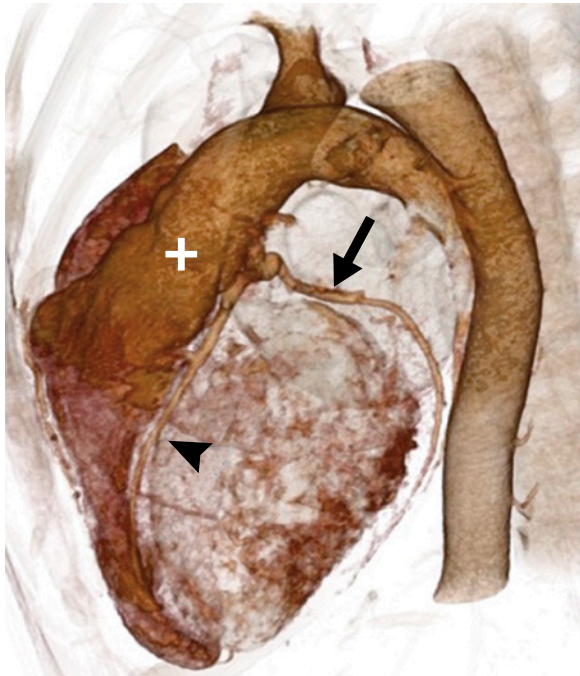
Three-dimensional CT volume rendering shows the left anterior descending coronary artery (arrowhead) and left circumflex coronary artery (arrow) arising from the left inferior pulmonary artery (+). Image courtesy of the authors.
